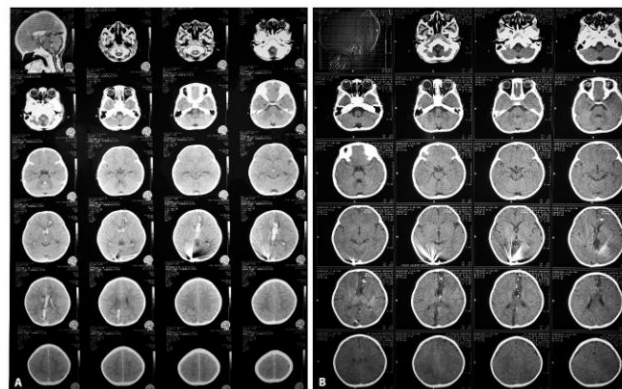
Head computed tomography for the first time came to the emergency room (A) and at the next two weeks after the incident (B)
